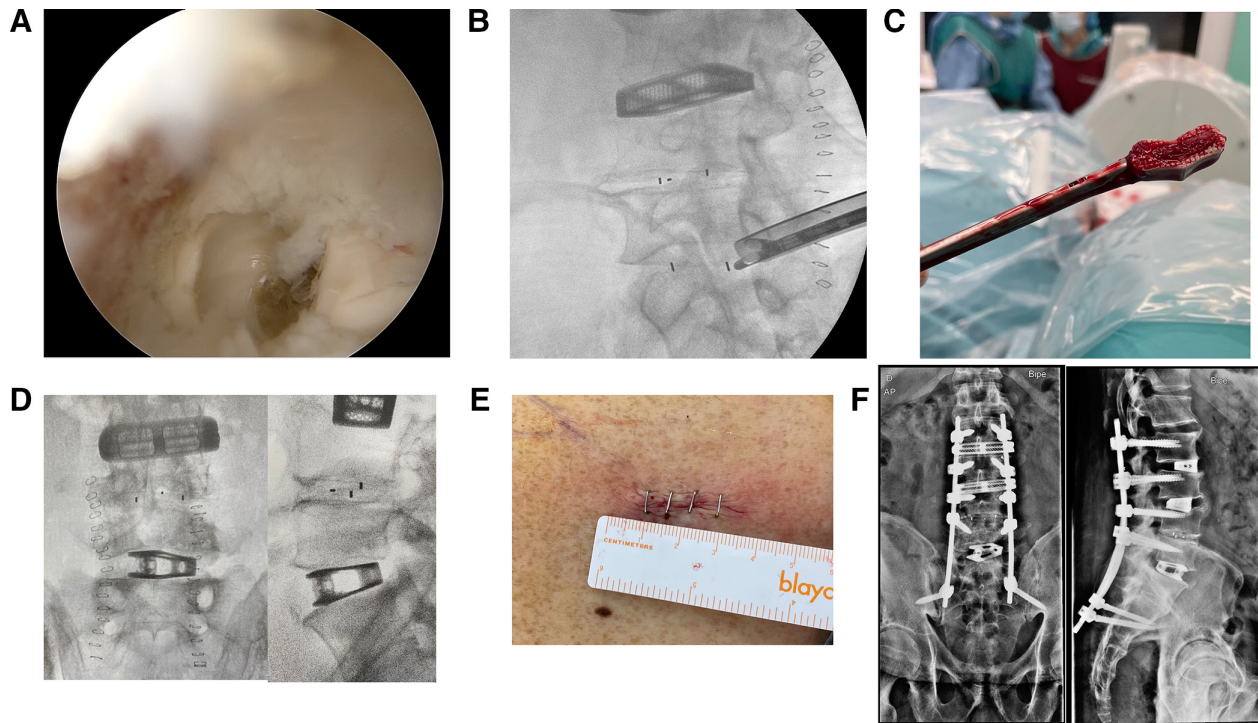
(A) An endoscopic view of the pseudarthrotic PEEK interbody cage. (B) Fluoroscopic lateral intraoperative view of a forceps grasping the interbody cage. A protective sleeve keeps the exiting nerve root protected. (C) Photograph of the removed interbody PEEK cage attached to the forceps. (D) Intraoperative fluoroscopic images of the lumbar spine in anterior/posterior (A/P) (left side) and lateral (right side) views. Notice the large footprint, expandable titanium cage that was placed as a substitute at L5-S1. (E) Skin incision of 2-cm length through which the PEEK interbody cage was removed, and the substitute large footprint expandable cage was placed into L5-S1 with the trans-Kambin approach. (F) Postoperative x-ray control images of the lumbar spine in A/P (left side) and lateral (right side) views.
